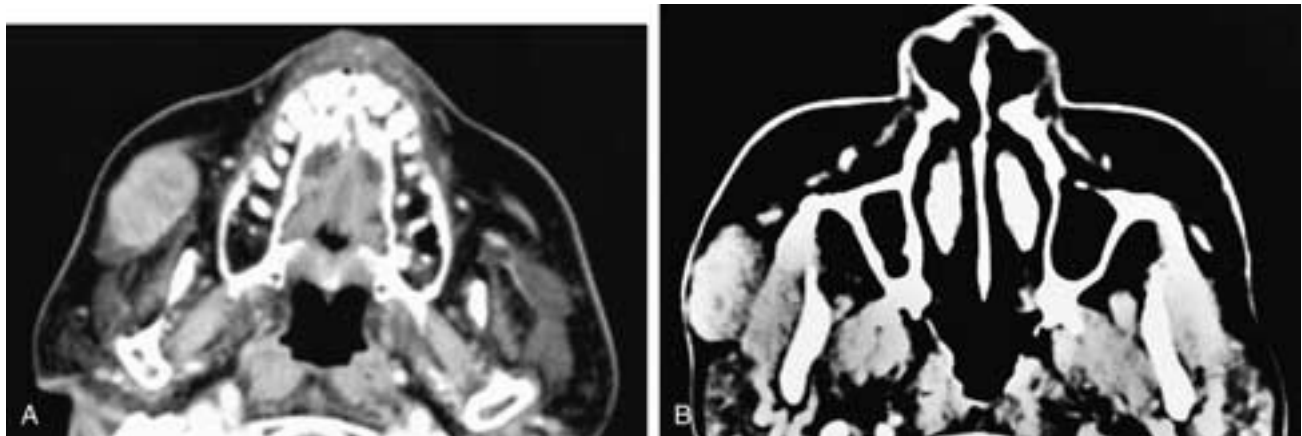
Axial CT scans (A, B) on two different patients, each with a slightly lobulated mass overlying the right masseter muscle. Both patients had pleomorphic adenomas of the accessory parotid glands.
